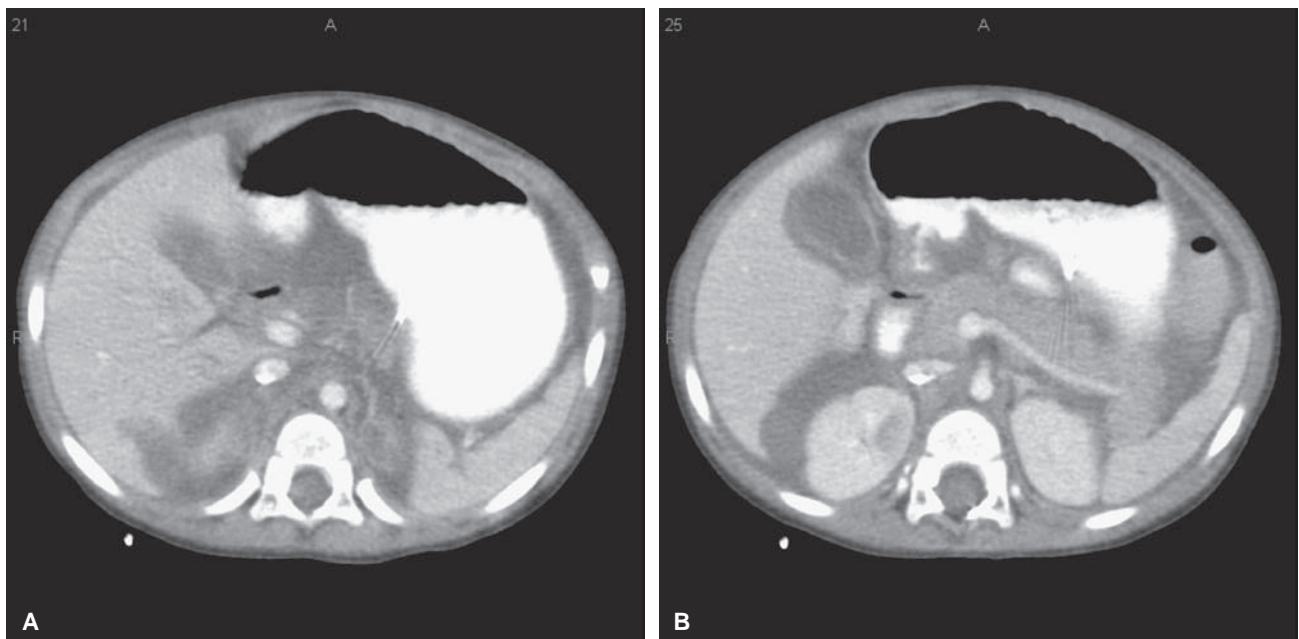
A: Abuse victim with computed tomographic (CT) scan evidence of injury to the liver and spleen. B: CT scan showing injury to the kidney and pancreas.
